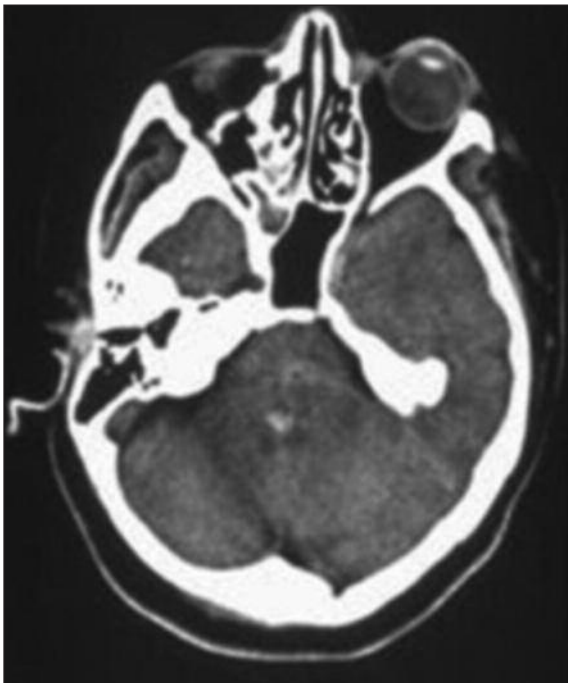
Diagnostic images of patient. Cranial CT images show hyperdense lesion in the bilateral basal-tegmental pontine area with breaking into a fourth ventricle.
